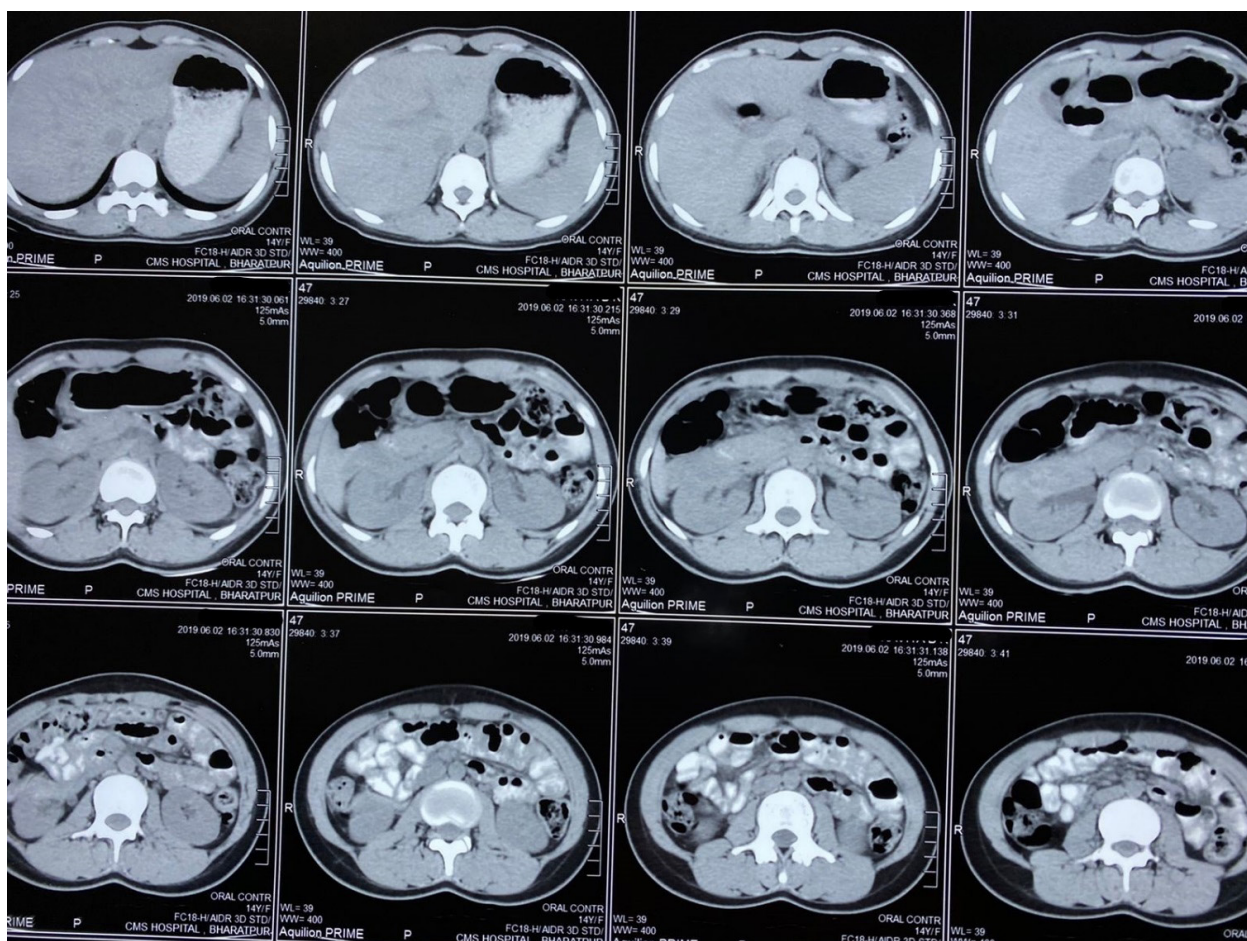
CT scan of abdomen and pelvis following resolution of cyst after five and half months.
